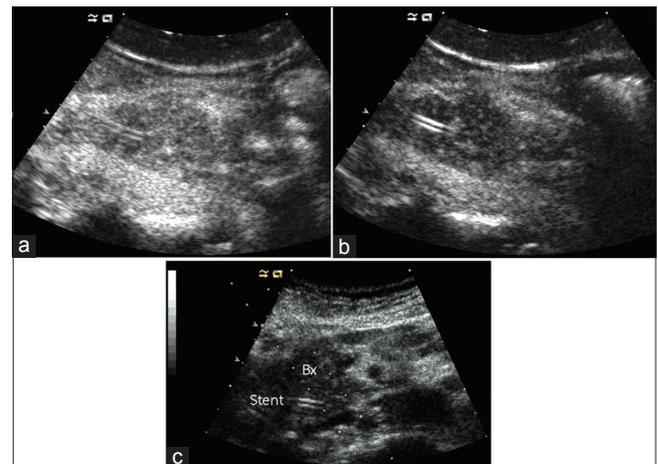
Focal autoimmune pancreatitis iso-enhancing in comparison to the surrounding pancreatic parenchyma in the arterial phase (a) and hypo-enhancing (wash-out) in the venous phase (b). Ultrasound-guided core biopsy is performed to confirm diagnosis (c). The stent is visualized in all images. Bx: Transcutaneous biopsy guidance
